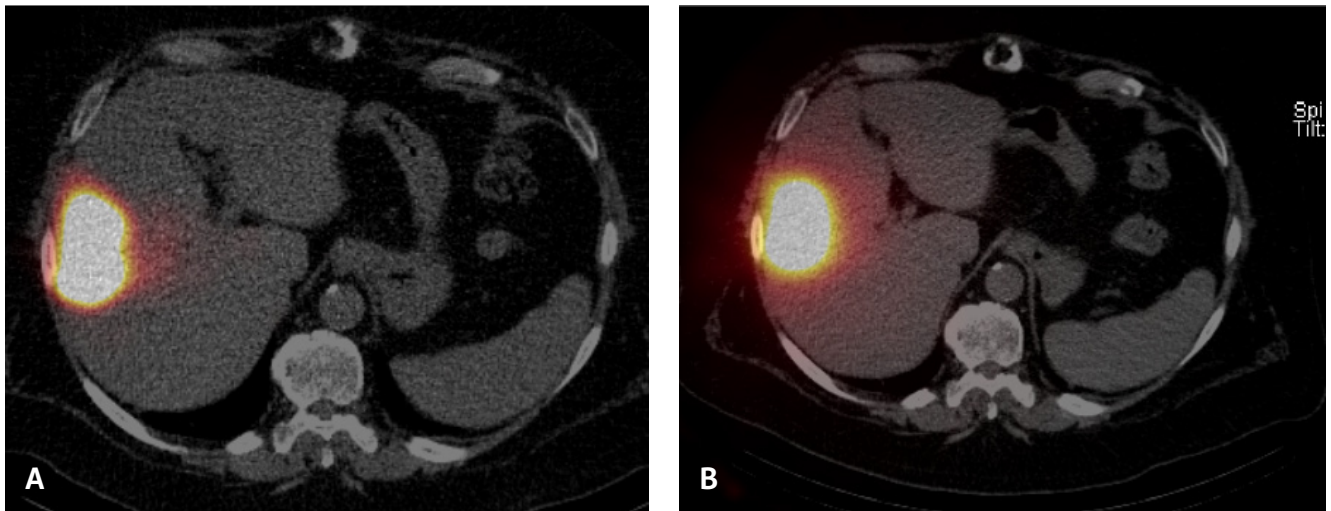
Post MAA shunt study, (A) SPECT-CT study showed localization of MAA to the expected right hepatic segment 5 and 8 regions with 5.53% lung shunt. Post Y-90 radioembolization, (B) SPECT-CT demonstrated localization of Y-90 glass beads to the expected right hepatic segment 5 and 8 areas without extrahepatic distribution.
